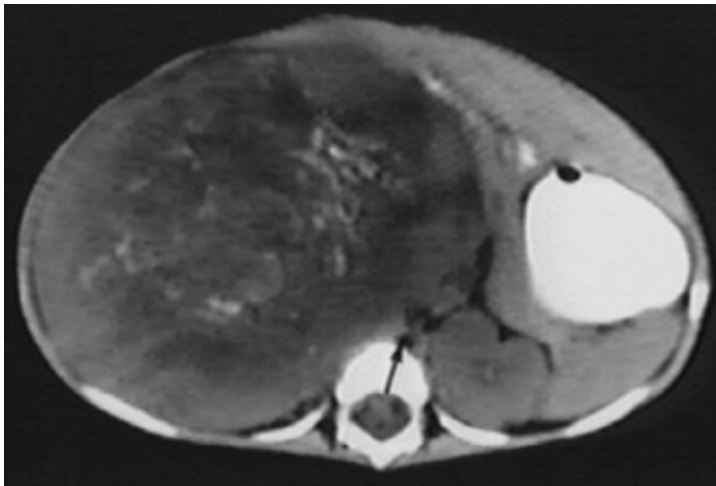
CT appearance of a nephroblastoma
